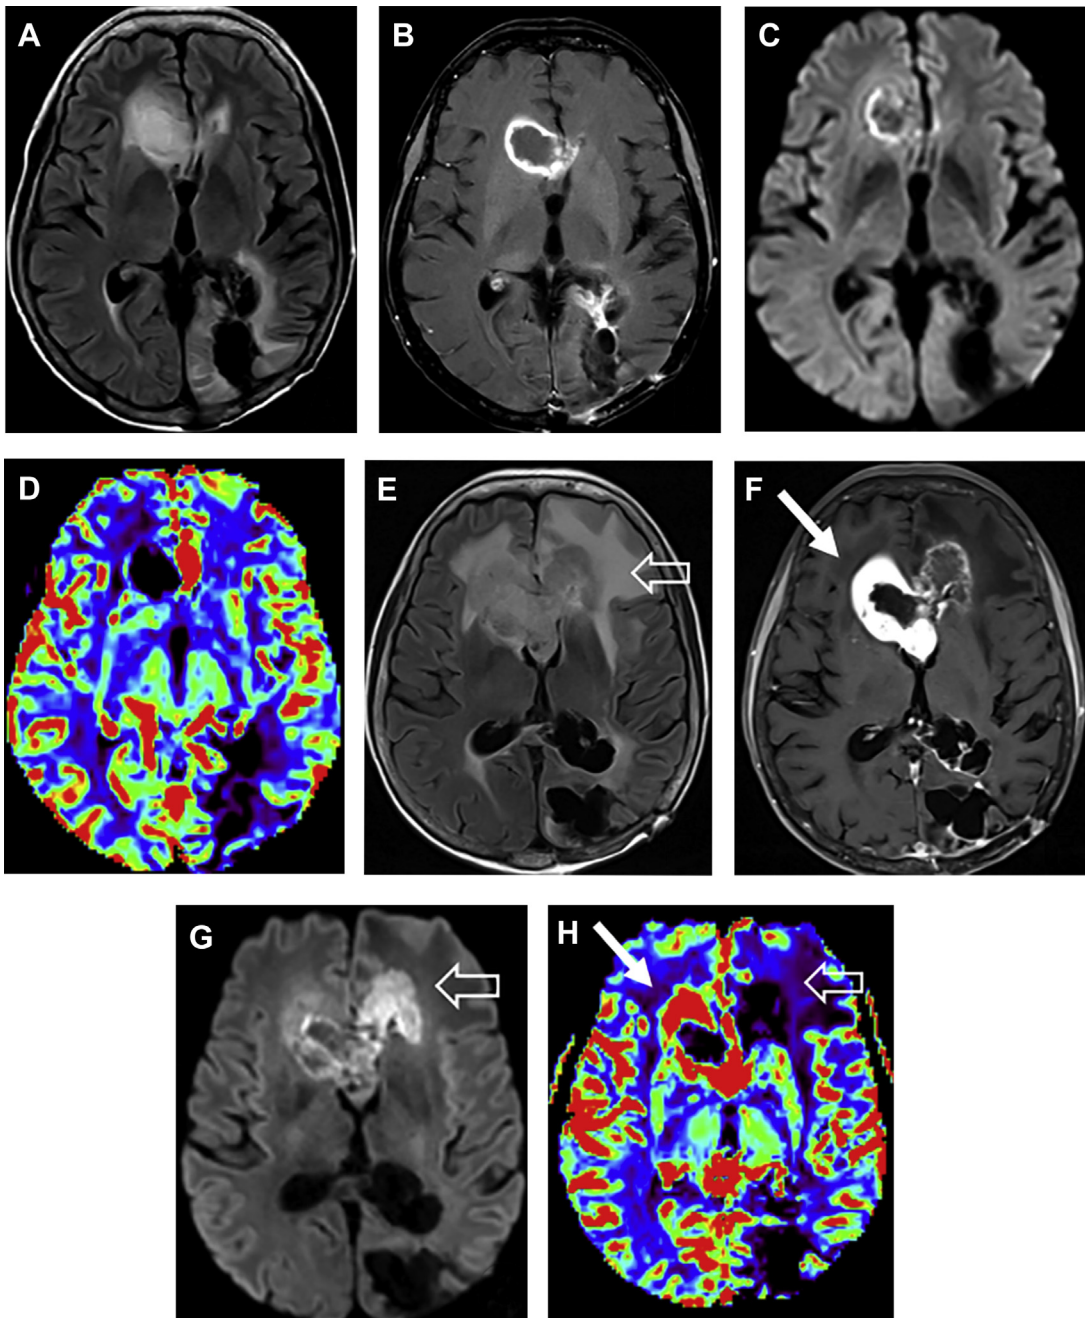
A 52-year-old woman presented with blurred and double vision with headaches. A mass was identified in the left parieto-occipital region, which proved to be glioblastoma, IDH1 wild-type, MGMT positive. Despite surgical resection, radiation, and chemotherapy, radiographic stability was limited. MR imaging at completion of treatment showed hyperintense T2 FLAIR signal in the right frontal lobe (A) corresponding with a rim enhancing and central necrotic lesion in the right frontal horn (B). Limited rim of diffusion signal was seen along the periphery (C) with no increased rCBV (D). After 4 months, true progression is shown in 2 different ways. On the right, the frontal mass has grown, shows greater hyperintense signal and thicker rim enhancement (*solid arrow, F*), without significant change in diffusion in the right frontal region (G), but with significantly greater rCBV corresponding with the area of enhancement (*solid arrow, H*), suggesting progressive disease. Similar progressive disease is also shown in the left frontal lobe by significantly increased edema and restricted diffusion (*open arrow, G*) with increase in enhancement (F); however, perfusion MR imaging does not show increased rCBV (*open arrow, H*).
